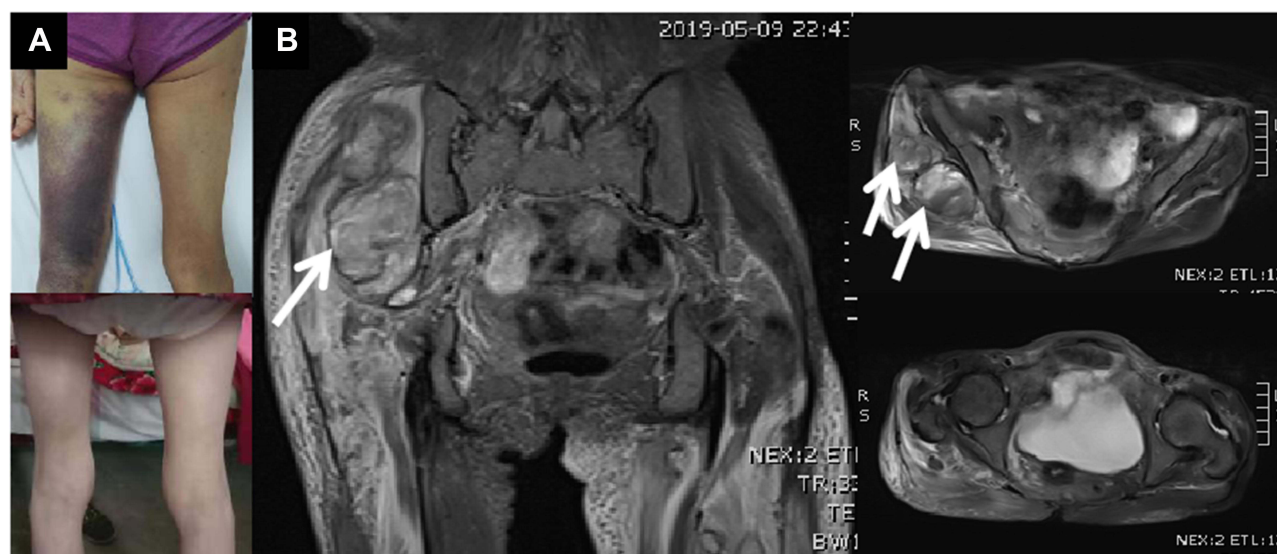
(A): The patient's right buttock and left thigh was obviously enlarged. There was ecchymosis over left thigh (above). The ecchymosis disappeared after 3 months (below). (B): T2 weighted imaging of magnetic resonance imaging showed occupying lesion (probably hematoma, see white arrows) deep under the right gluteus maximus, and the signal of muscles and other soft tissues around the pelvis and femur increased widely.
